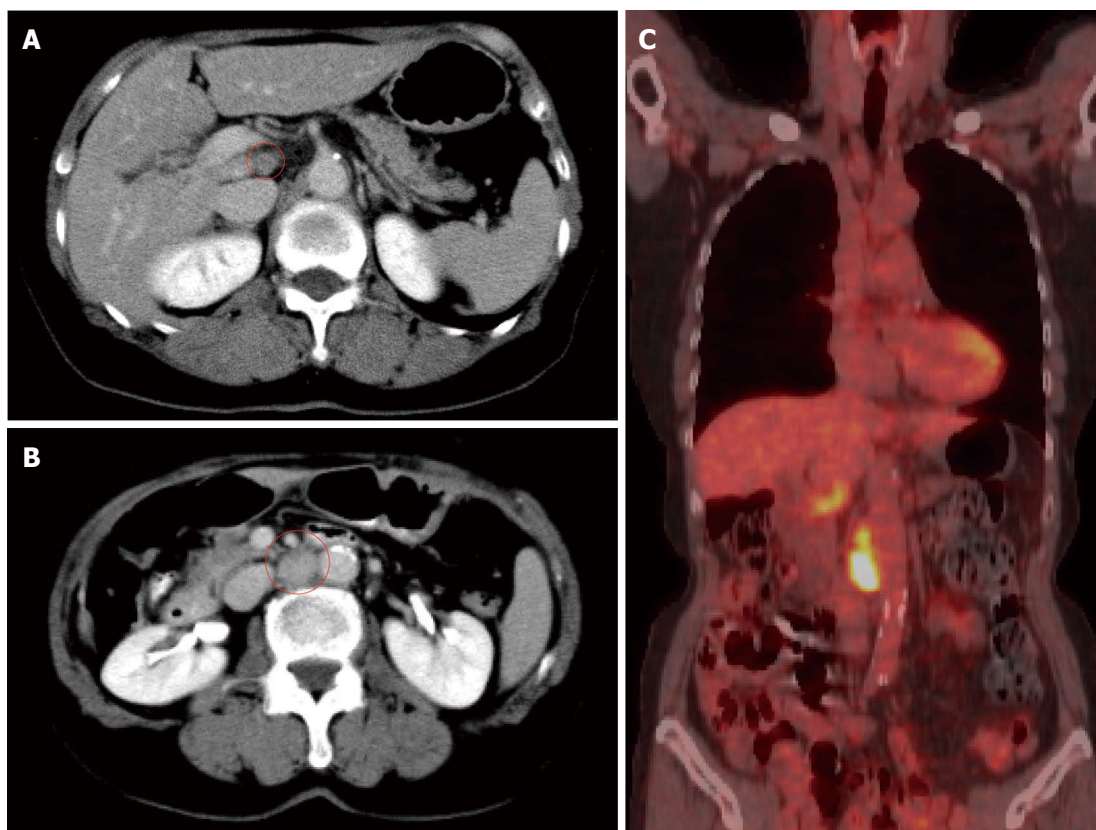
Computed tomography detected a 20 mm of para-aortic lymph node metastasis and a 10 mm of lymph node metastasis at the hepato-duodenal ligament (A and B); and Positron emission tomography was performed and detected the recurrences at the same lesions (C).
